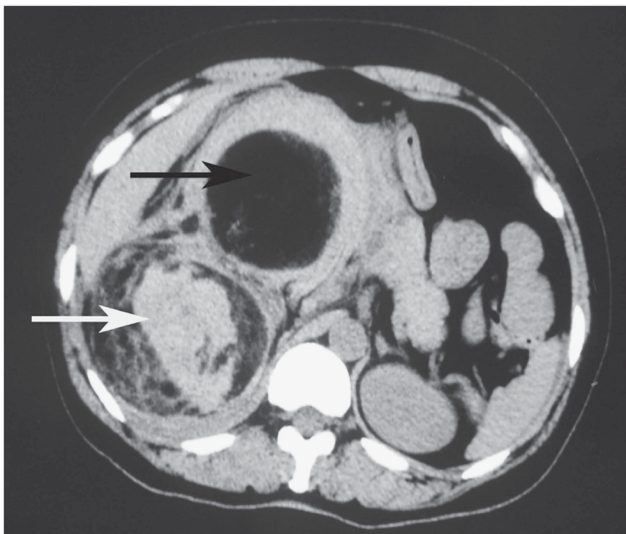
Abdominal computed tomography without contrast medium showed two masses in the right renal region (white arrow) and perirenal area (black arrow). Density of the mass in the center area was relatively low in comparison with the periphery.
